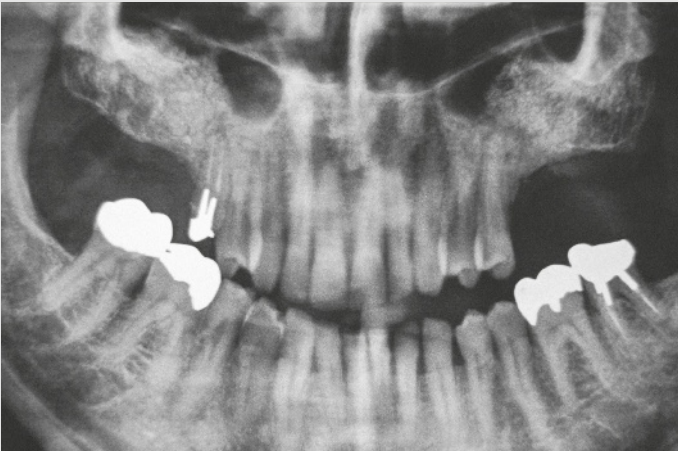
Panoramic radiographic control 4 months post-operatively (a bilateral sinus elevation has been performed).
